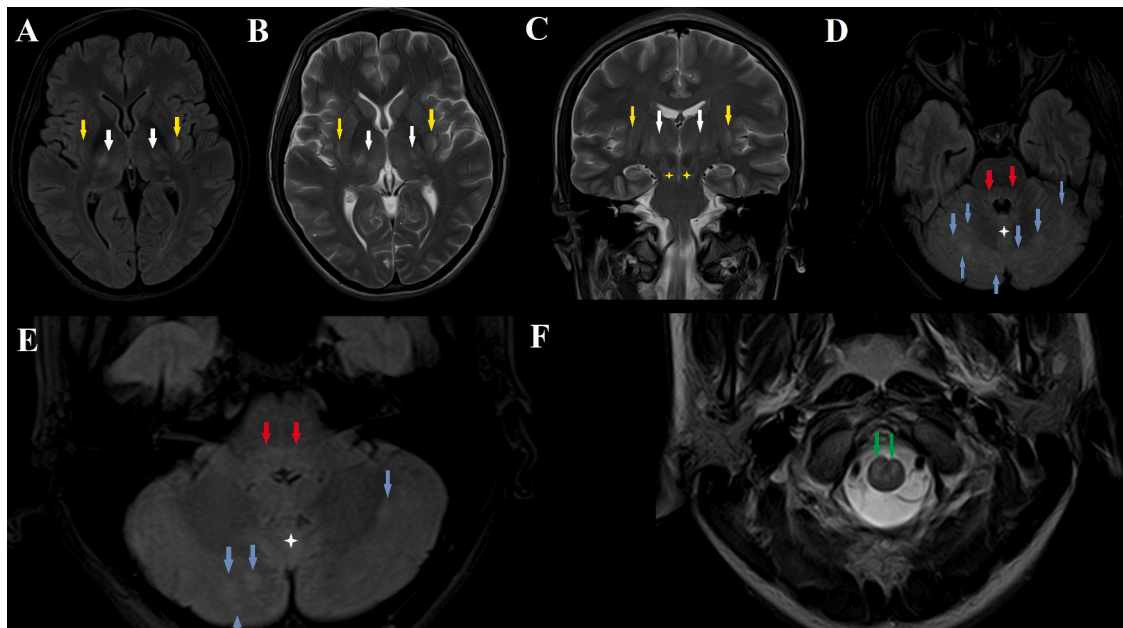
Initial MRI of the brain of a 24-year-old woman diagnosed with TBE. Axial FLAIR (A,D,E), axial T2-weighted (B,F) and coronal T2-weighted images (C) depict: bilaterally quite symmetric hyperintense areas in the thalami (white arrows) and the posterior putamina (yellow arrows), bilateral and symmetric hyperintense signal at the midbrain, sparing the red nucleus and substantia nigra (yellow asterisk) (C), hyperintense signal in the dorsal pons (red arrows) and within cerebellar vermis (white asterisk), and also several cortical-subcortical/leptomeningeal hyperintensities involving cerebellum cortex bilaterally (blue arrows). The last image (F) show bilateral symmetric hyperintense signal at the level of the junction of medulla and spinal cord (green arrows). These lesions did not demonstrate restricted diffusion on DWI/ADC sequences (not shown).
